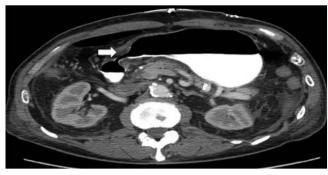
Computed tomography (CT) image of the abdomen showing circumferential antral thickening (arrowhead).
